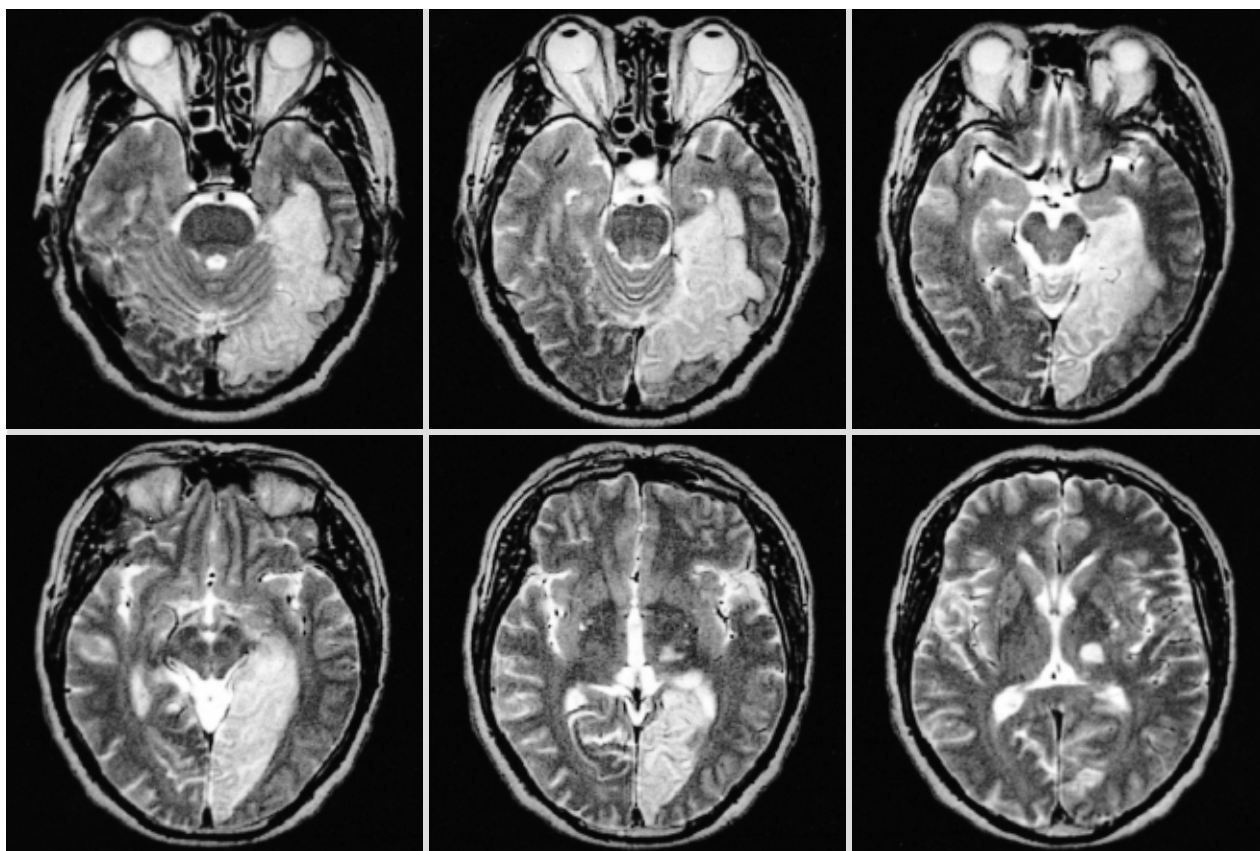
T2-axial brain MR images show an infarct involving the left lingual, fusiform, and parahippocampal gyri and a lacune in the left thalamus.
